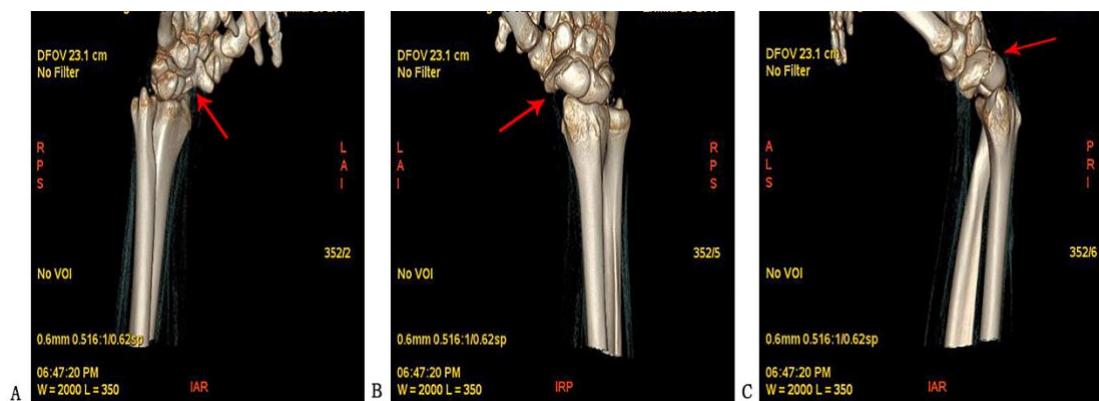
CT scan of the patient established the fracture of scaphoid (the red arrow indicates the location of fracture). A. Palmar view. B. Dorsal view. C. Lateral view.
